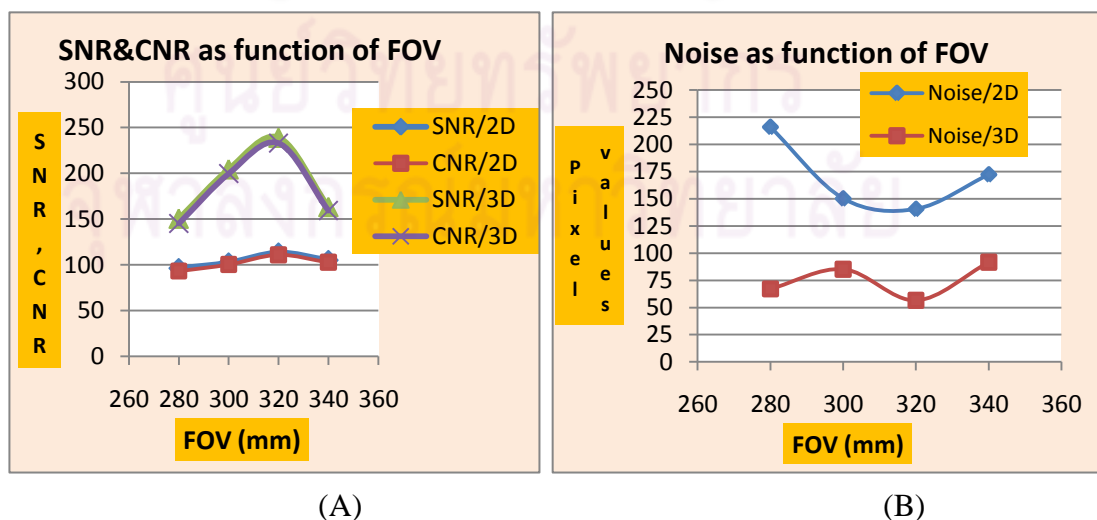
The SNR & CNR (A) and noise (B) as function of FOV on 2D and 3D coronal plane MRCP imaging at MRI 0.4 T
